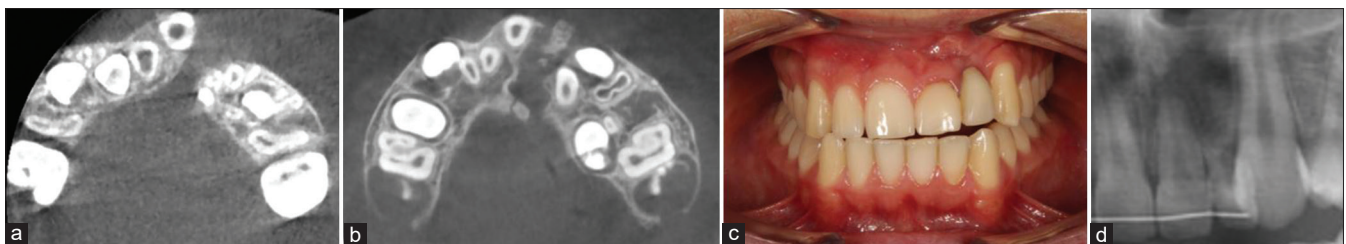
Cone-beam computed tomography views: (a) Baseline status (prior to grafting) and (b) After grafting, Month 7 (note sequester and massive bone loss). Periodontal problems (lateral incisor) after early secondary bone grafting: (c) Gross inspection and (d) Radiographic evidence of root resorption
